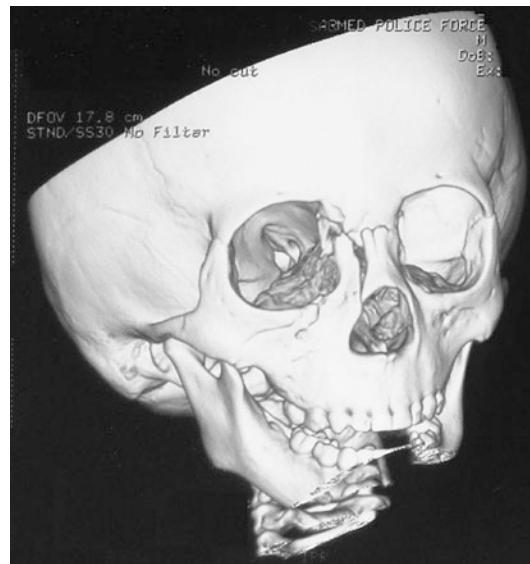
CT three-dimensional reconstruction showed there were fractures in lacrimal fossa and bony nasolacrimal duct in the medial wall of the right orbital
